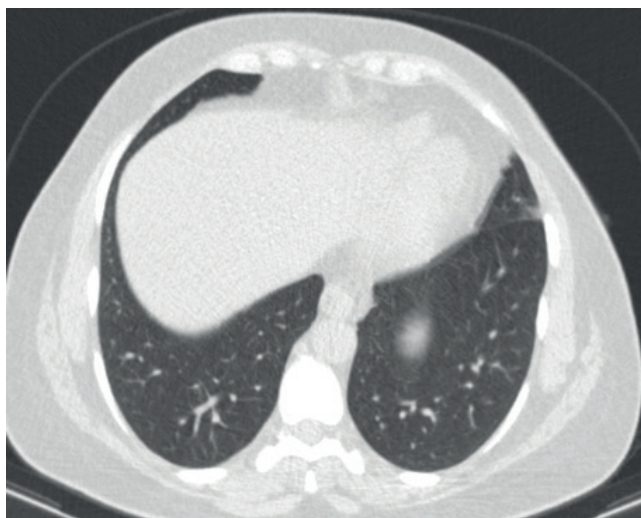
Axial CT Image of the Chest Showing A Minimal Ground-glass Opacity.
